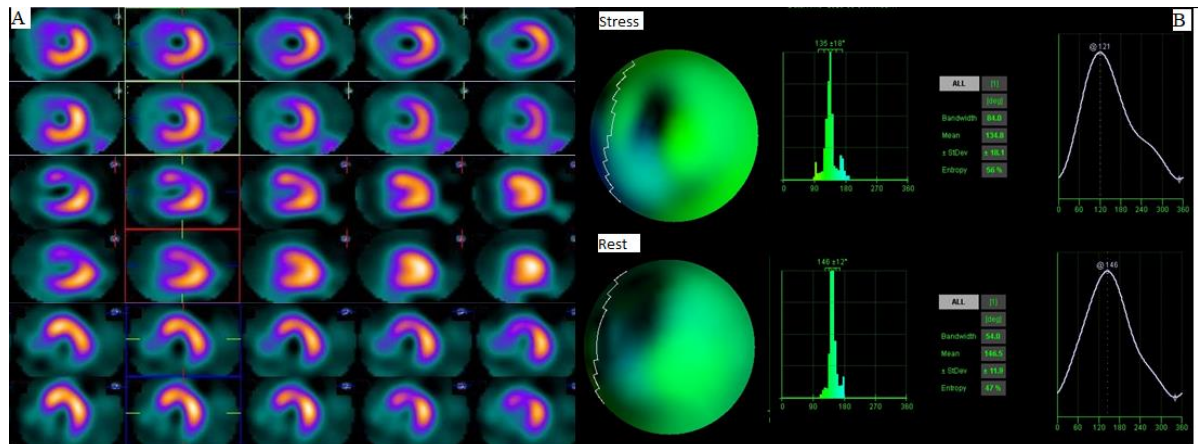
The stress-rest gated myocardial perfusion image shows severe ischemia in the anterior and mid-septal walls. (A) The image shows phase analysis for left ventricular mechanical synchronism assessment by myocardial perfusion single-photon emission computed tomography. In phase analysis, the wide bandwidth can be observed over the histogram with evidence of mechanical dyssynchrony in the left ventricle in a patient with a history of myocardial infarction (B) based on the data obtained in this study.
